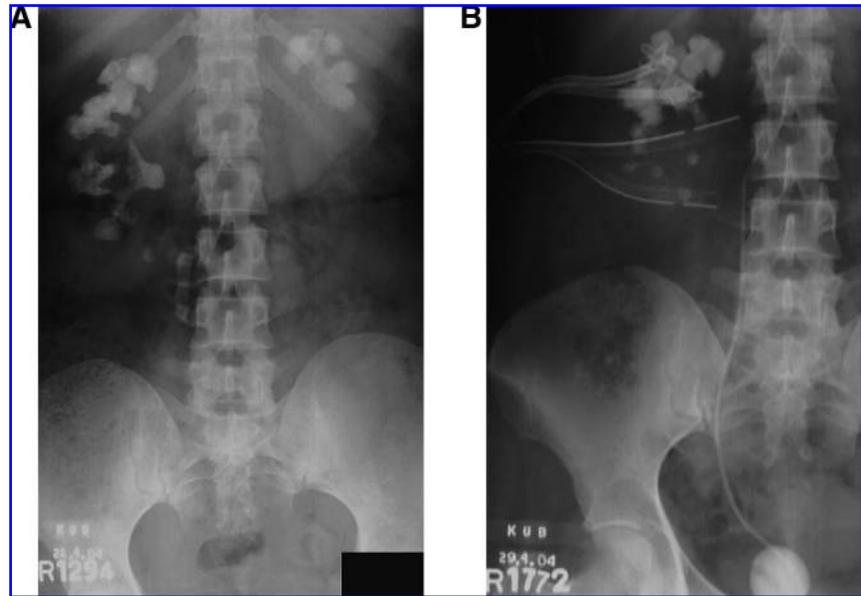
(A) Radiograph of the kidneys, ureters, and bladder. (B) Initial preplaced tracts and partial clearance in stage 1.
